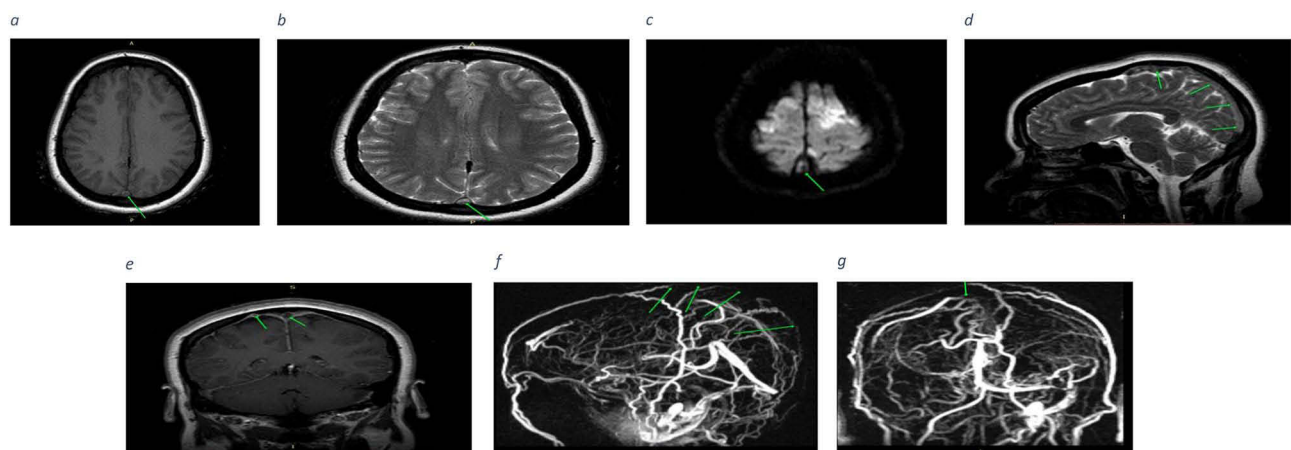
(a) Axial T1WI-SE brain MRI shows slightly high signal intensity of superior sagittal sinus posteriorly (arrow) compared to cerebral white matter. (b) and (c) Axial T2-weighted and Diffusion-weighted Imaging (DWI) Brain MRI depicting high signal intensity along the posterior aspect of the superior sagittal sinus (indicated by arrows) respectively. (d) and (e) Sagittal T2-weighted spin echo (T2WI- SE) and coronal T1-weighted spin echo (T1WI-SE) brain MRI demonstrating hyperintensity along the posterior aspect of the superior sagittal sinus and the right vein of Trolard (superior anastomotic vein) respectively. (f) and (g) The MRV reveals a focal absence of blood flow (filling defect) along the posterior portion of the superior sagittal sinus and the right vein of Trolard (superior anastomotic vein).
